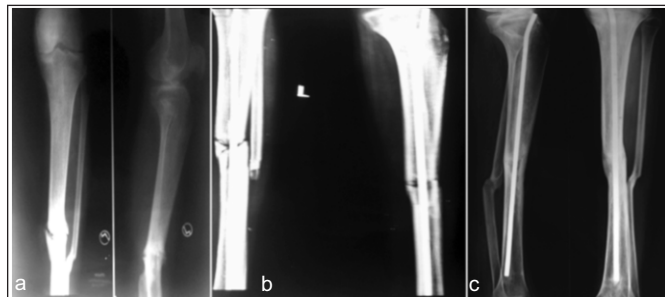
(a) Pre-operative radiograph of a patient with infected nonunion of tibia, (b) post-operative radiograph after debridement and antibiotic cement-coated nailing, and (c) radiograph showing bony union achieved at 28 weeks.
